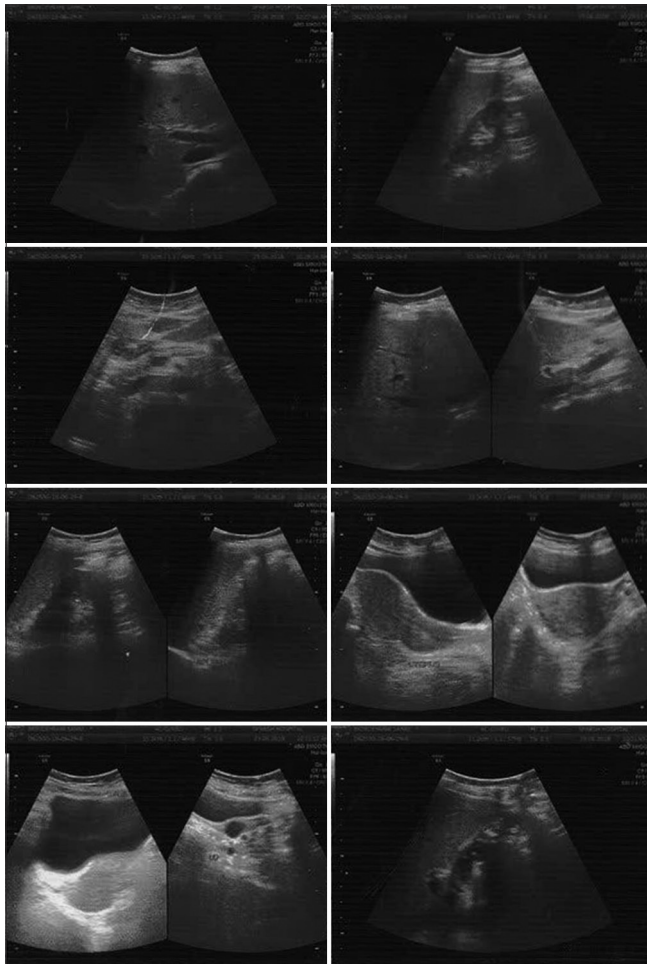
Ultrasonography film before treatment
